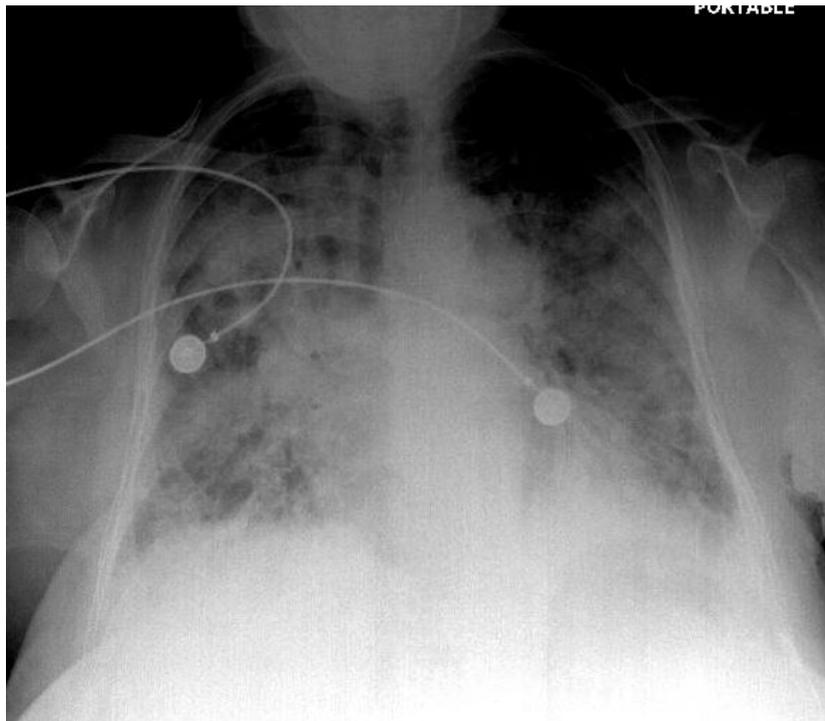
Chest radiography of the patient consistent with bilateral pulmonary edema
